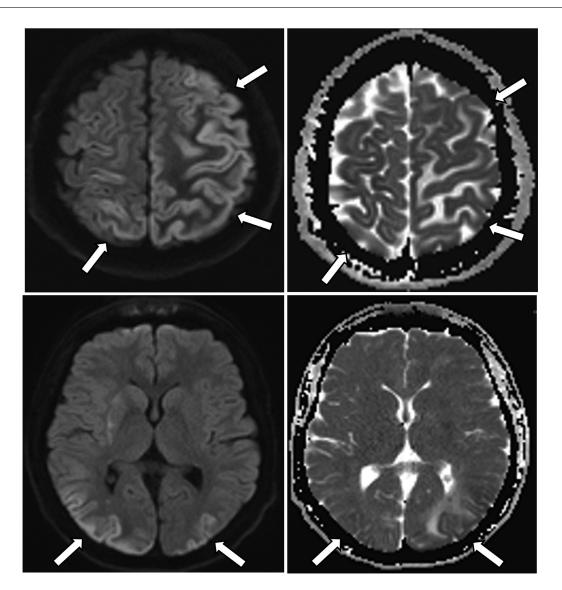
Axial MR, DWI, and ADC images demonstrating diffuse bilateral acute/subacute infarcts, as demonstrated by the white arrows. Pattern of cortical restricted diffusion with subcortical white matter vasogenic edema has been described in another case of cerebral air embolism [1].
